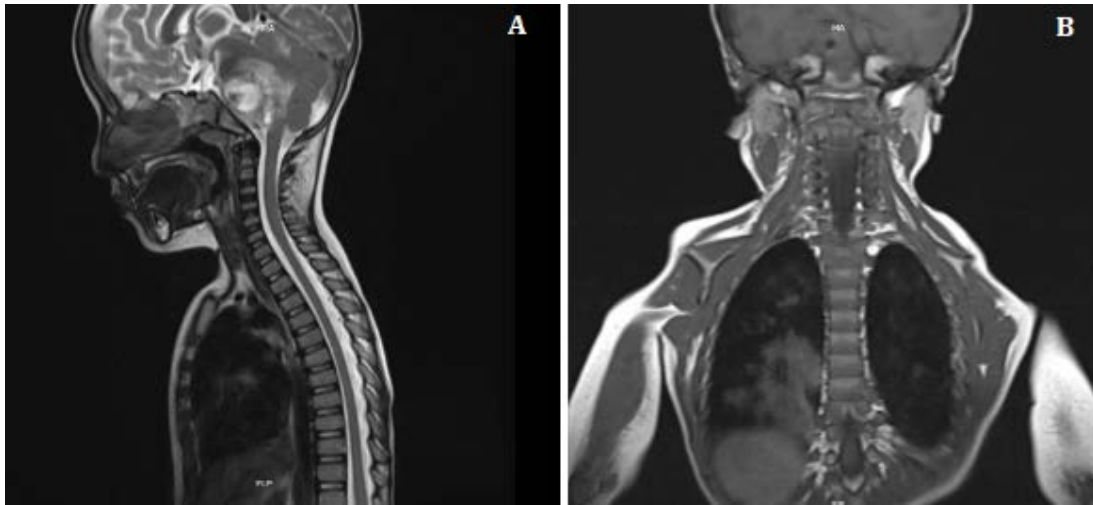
2-year-old male with medulloblastoma. FINDINGS: Axial (A) and coronal (B) post-surgical contrast-enhanced cervical spine MRI that shows inespecific soft tissue edema in the nuchal region and right side of the neck, with fluid collection in the soft tissues adjacent to the surgical site. Partially visualized mass with cystic and solid component on the right side of the peritroncal cisterns. TECHNIQUE: 1.5T equipment. Radiofrequency pulse sequences with techniques including SE, TSE, FE, or IR. Source: Patient’s medical chart, 2023.
